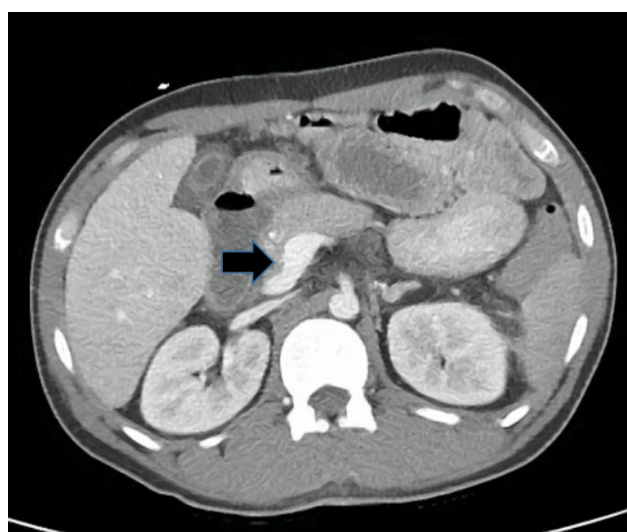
Abdominopelvic CT revealed a porto-duodenal shunt (arrow) draining from the superior mesenteric vein into the inferior vena cava.
